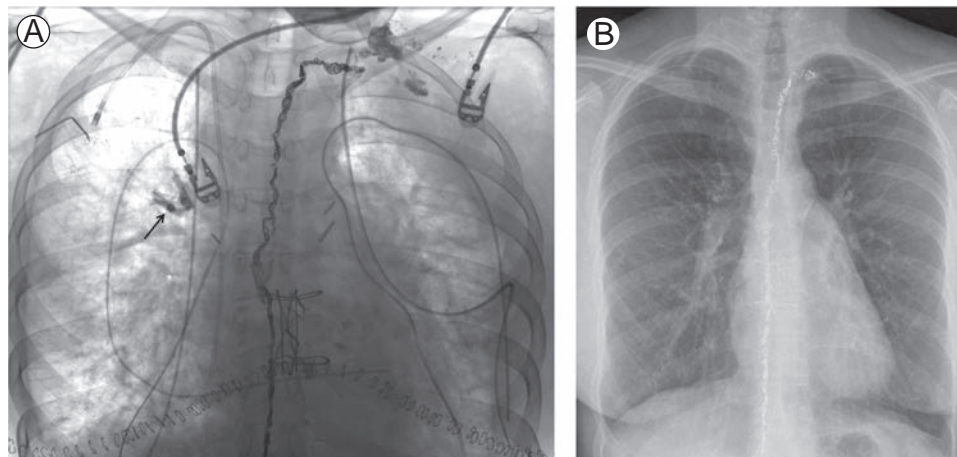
Patient with cystic fibrosis who underwent bilateral lung transplantation and subsequently developed increasing right chylous pleural effusion. Postembolization image of the chest shows coils throughout the thoracic duct and n-BCA glue filling within their open spaces (A). Nontarget embolization of glue that leaked through the coils, into the left subclavian vein, and finally was trapped in right upper lobe pulmonary artery branches has a crown-like appearance (arrow). Subsequent chest radiograph obtained approximately 2.5 years later for unrelated reasons shows coils along the course of the thoracic duct and resorption of the right upper lobe glue (B).
